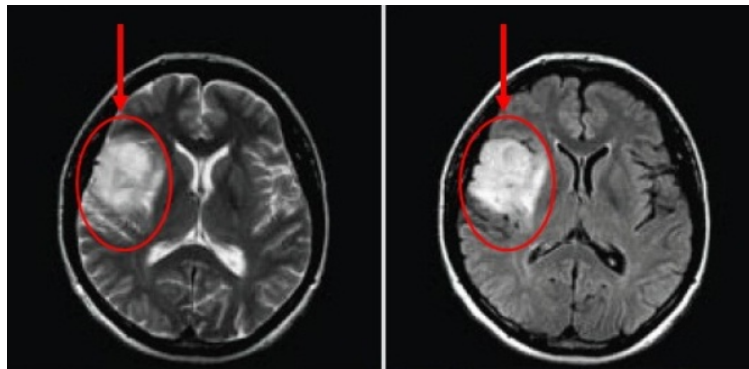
MRI image of brain tumor
